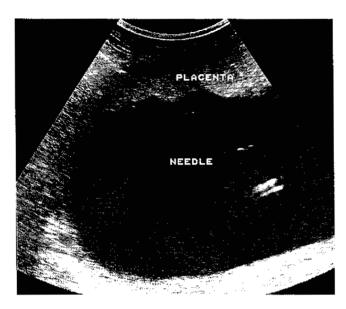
Ultrasound-guided amniocentesis showing transplacental route which is sometimes unavoidable.
